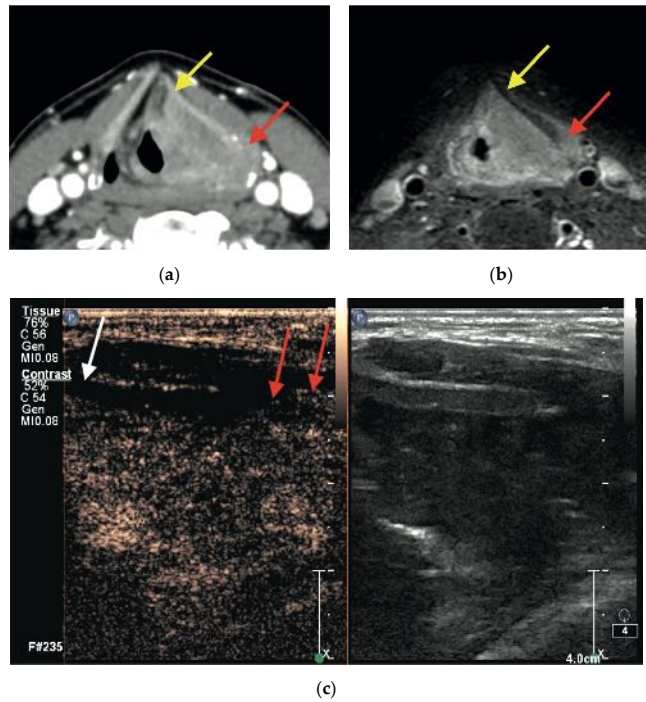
Supraglottic squamous cell carcinoma on the left side. (a) Axial CECT represents two sites, namely, sites that were false-positive anteriorly (yellow arrow) and true-positive posteriorly (red arrow), whereas MRI (b) contrast-enhanced high-resolution T1-weighted turbo spin echo Dixon and CEUS (c) findings were true-negative anteriorly (white arrow) and true-positive posteriorly (red arrows), respectively.
